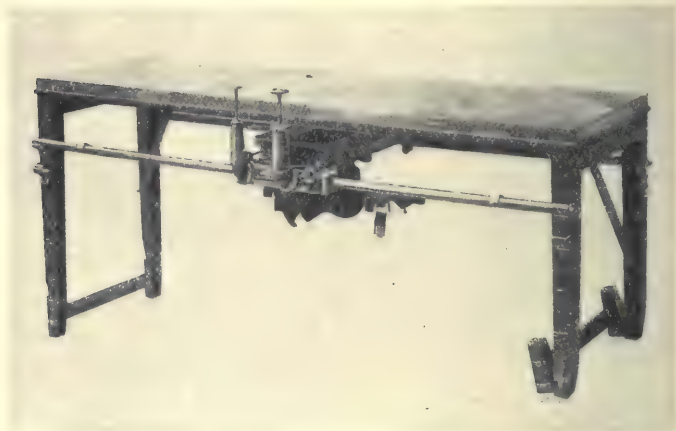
X-ray surgical table by Dr. Réchou. It will be noticed that the arrangement of the legs allows of two different heights and a certain range in angle.
